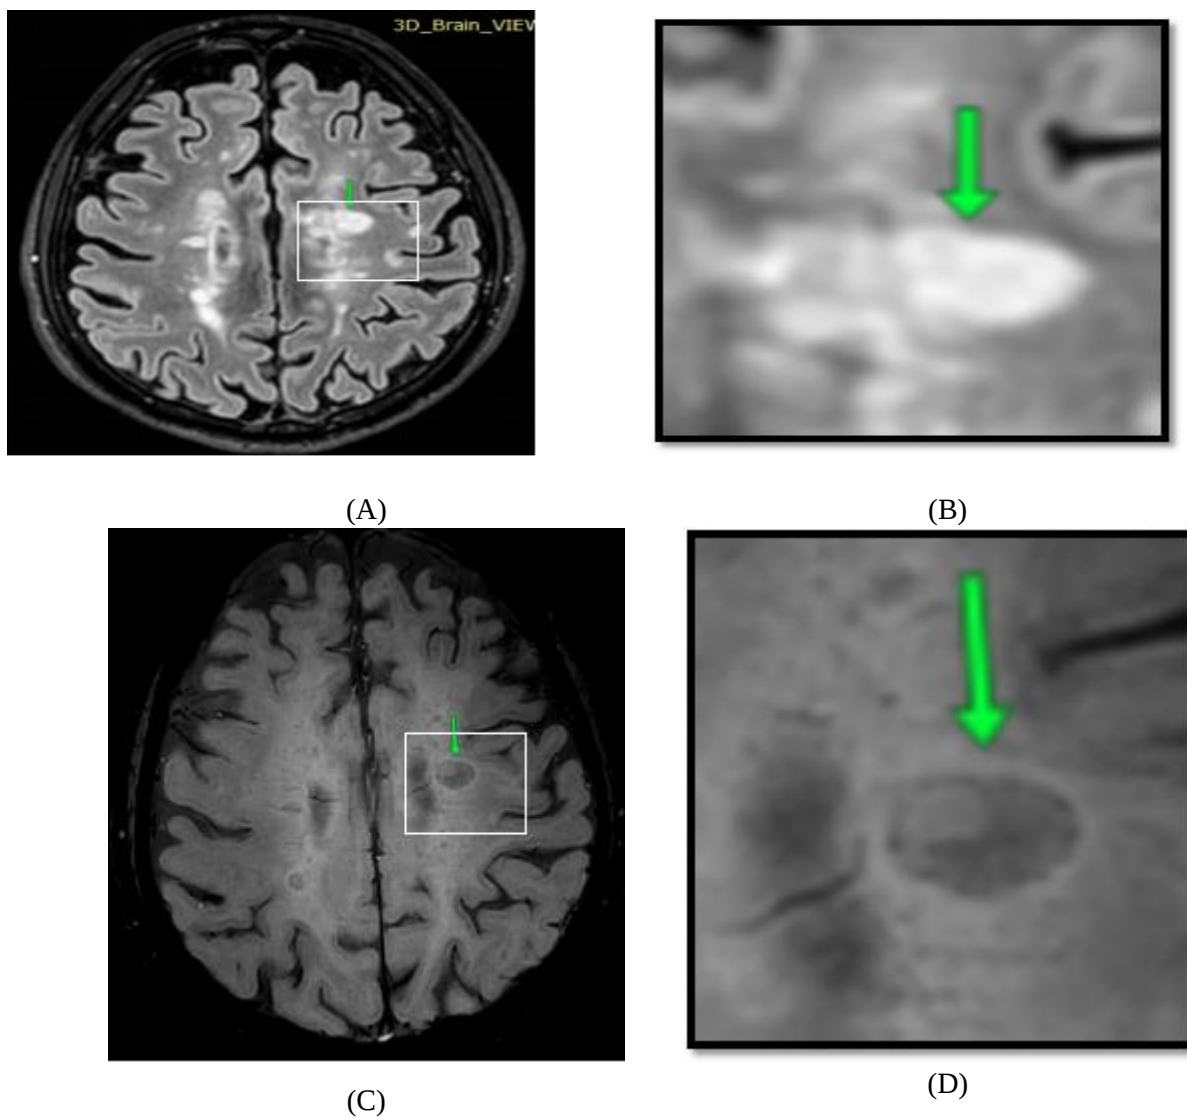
A) Axial 3D FLAIR showed multiple bilateral periventricular demyelinating hyperintense foci. (Arrow). B) A sagittal periventricular demyelinating hyperintense focus. (Arrow). C) Axial SWI paramagnetic rim sign (green arrow) was clearly demonstrated in one of the periventricular lesions. D) Axial SWI central vein sign (black arrow) was clearly demonstrated in one of the periventricular lesions.
